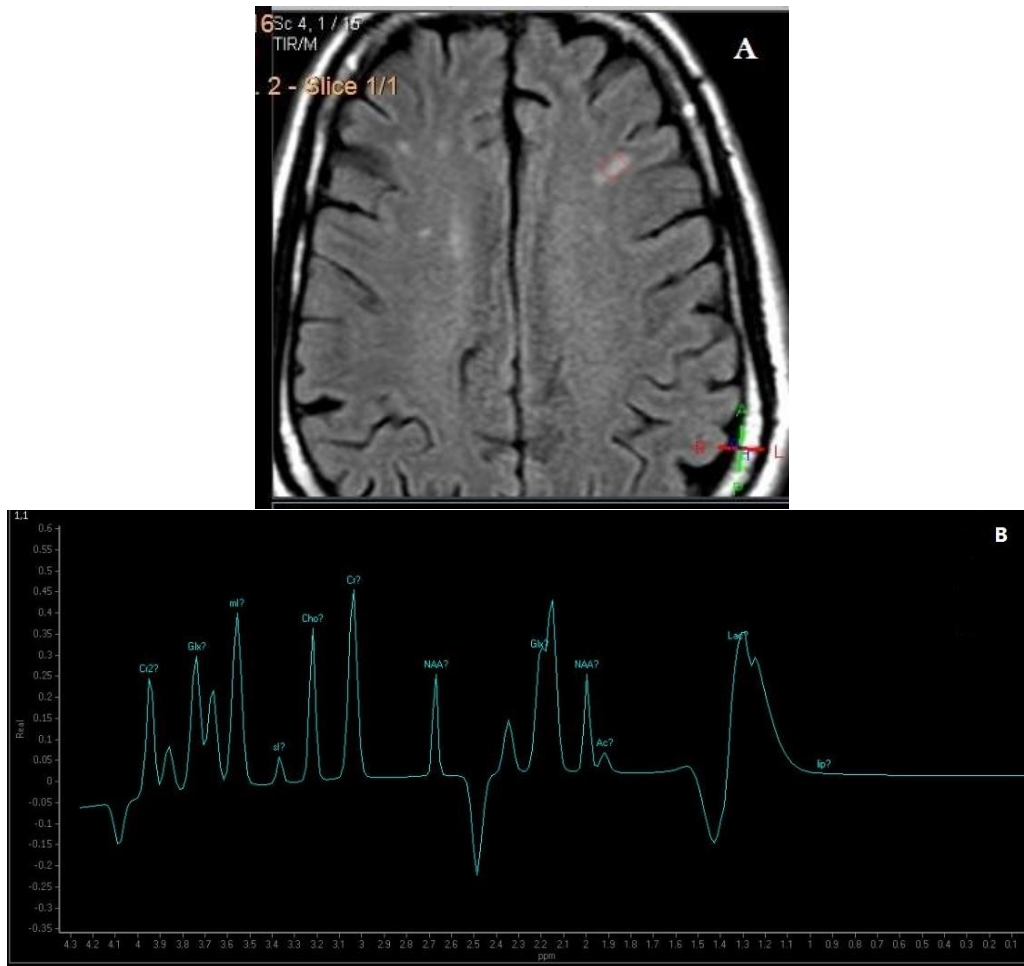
45 years old male patient presented with ischemic stroke. Axial FLAIR (A) showing bilateral frontal subcortical WML. (B): MRS depicting decrease of the NAA peak, mild decrease in Cho peak, with elevation of lip/lact peak. mI/Cr ratio 0.91, Cho/Cr 1.12, Cho/NAA 1.61.
